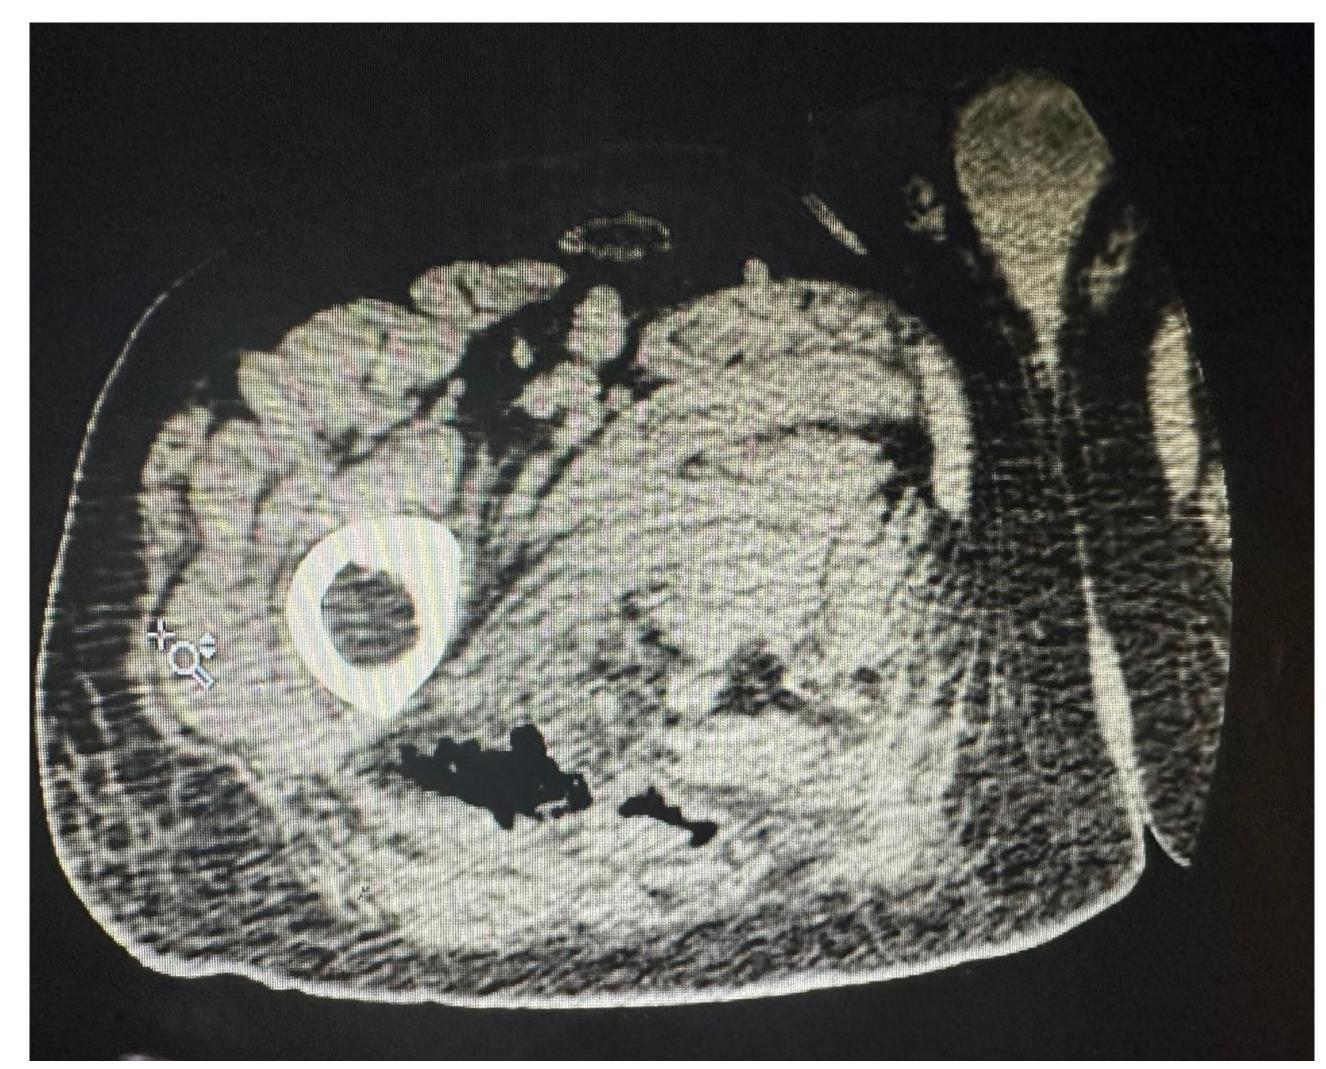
Gaseous collection noted on CT right femur.
